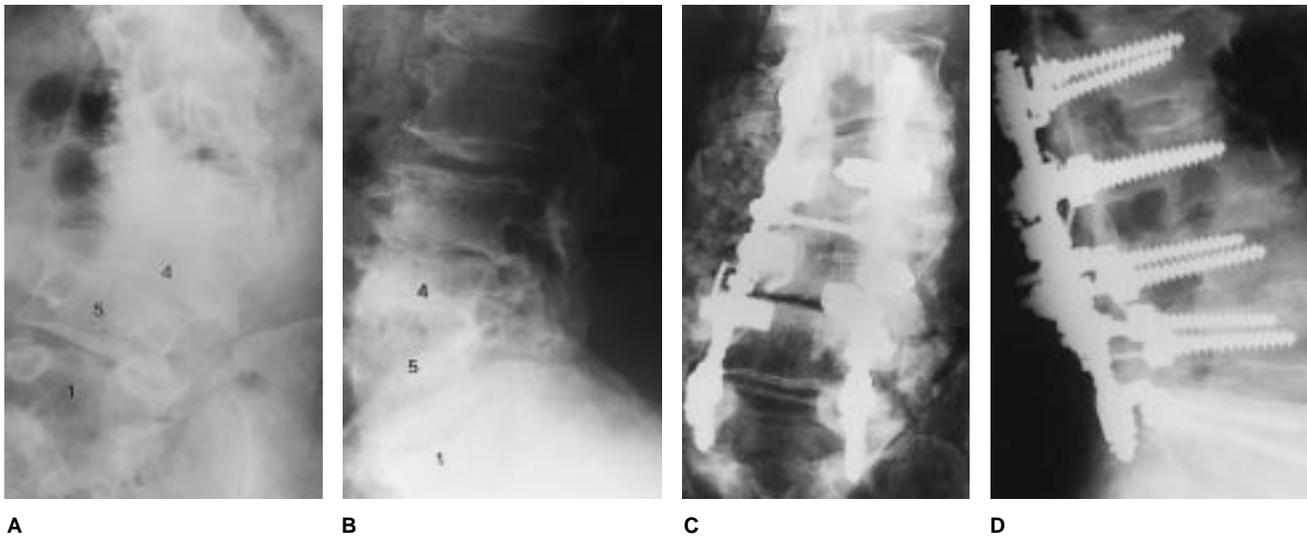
Anteroposterior (AP) (A) and lateral (B) plain radiographs of an adult patient with neurogenic claudication reveal a left lumbar degenerative scoliotic curve with significant lateral listhesis at L4-5. The patient underwent a posterior lumbar decompression with partial reduction of the L4-5 lateral listhesis and posterolateral fusion from L2 to S1 performed with use of pedicle-screw fixation, as depicted in AP (C) and lateral (D) radiographs.
